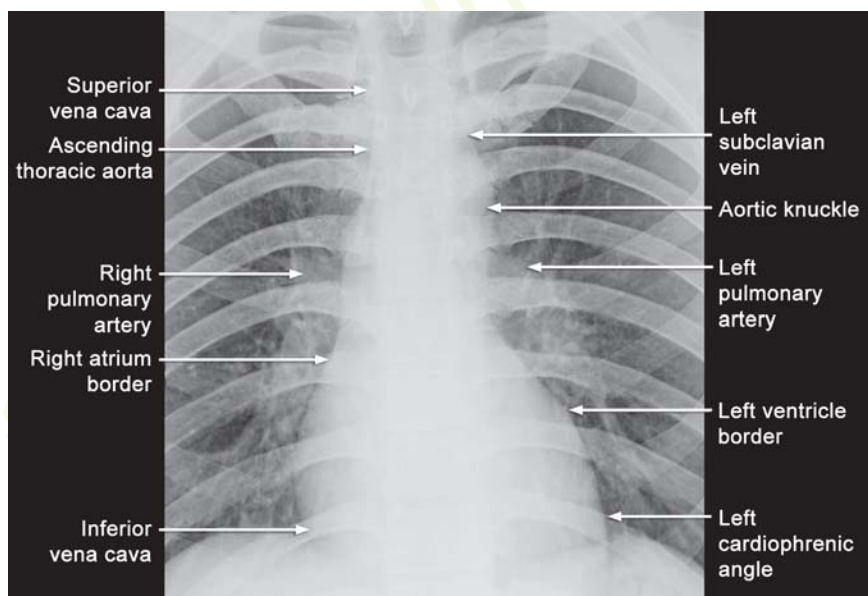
X-ray chest PA view shows mediastinal borders
